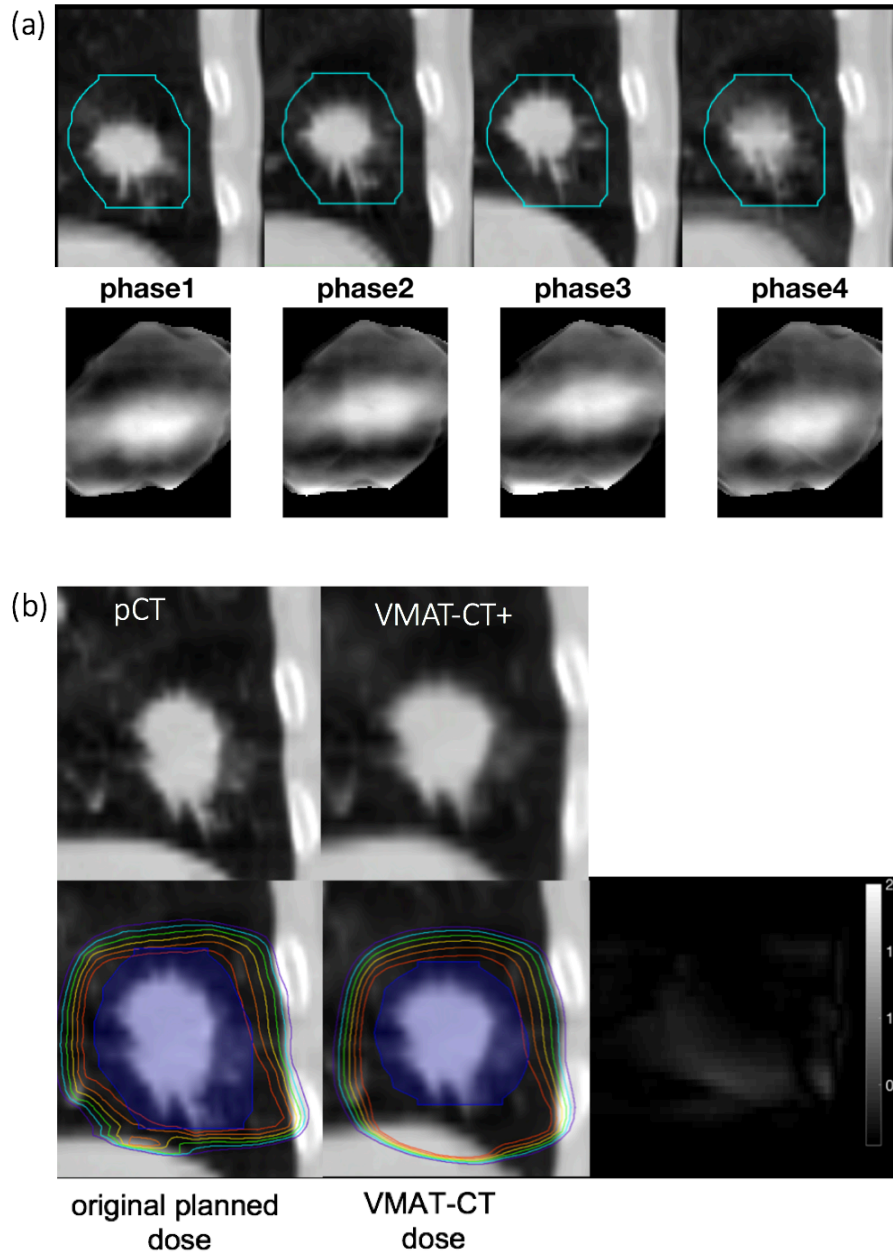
Dose comparison on SBRT patient. (a) comparison between 4D CT and 4D VMAT-CT. (b) (Top row) comparison of planning CT, mean position VMAT-CT+; (bottom row) dose distributions in the original plan, dose based on 4D VMAT-CT+, 3D Gamma plot of comparison between 4D VMAT-CT dose and original planned dose, and 3D Gamma plot of comparison between 4D VMAT-CT dose and original planned dose. The blue shaded area is the original or deformed PTV contour.
